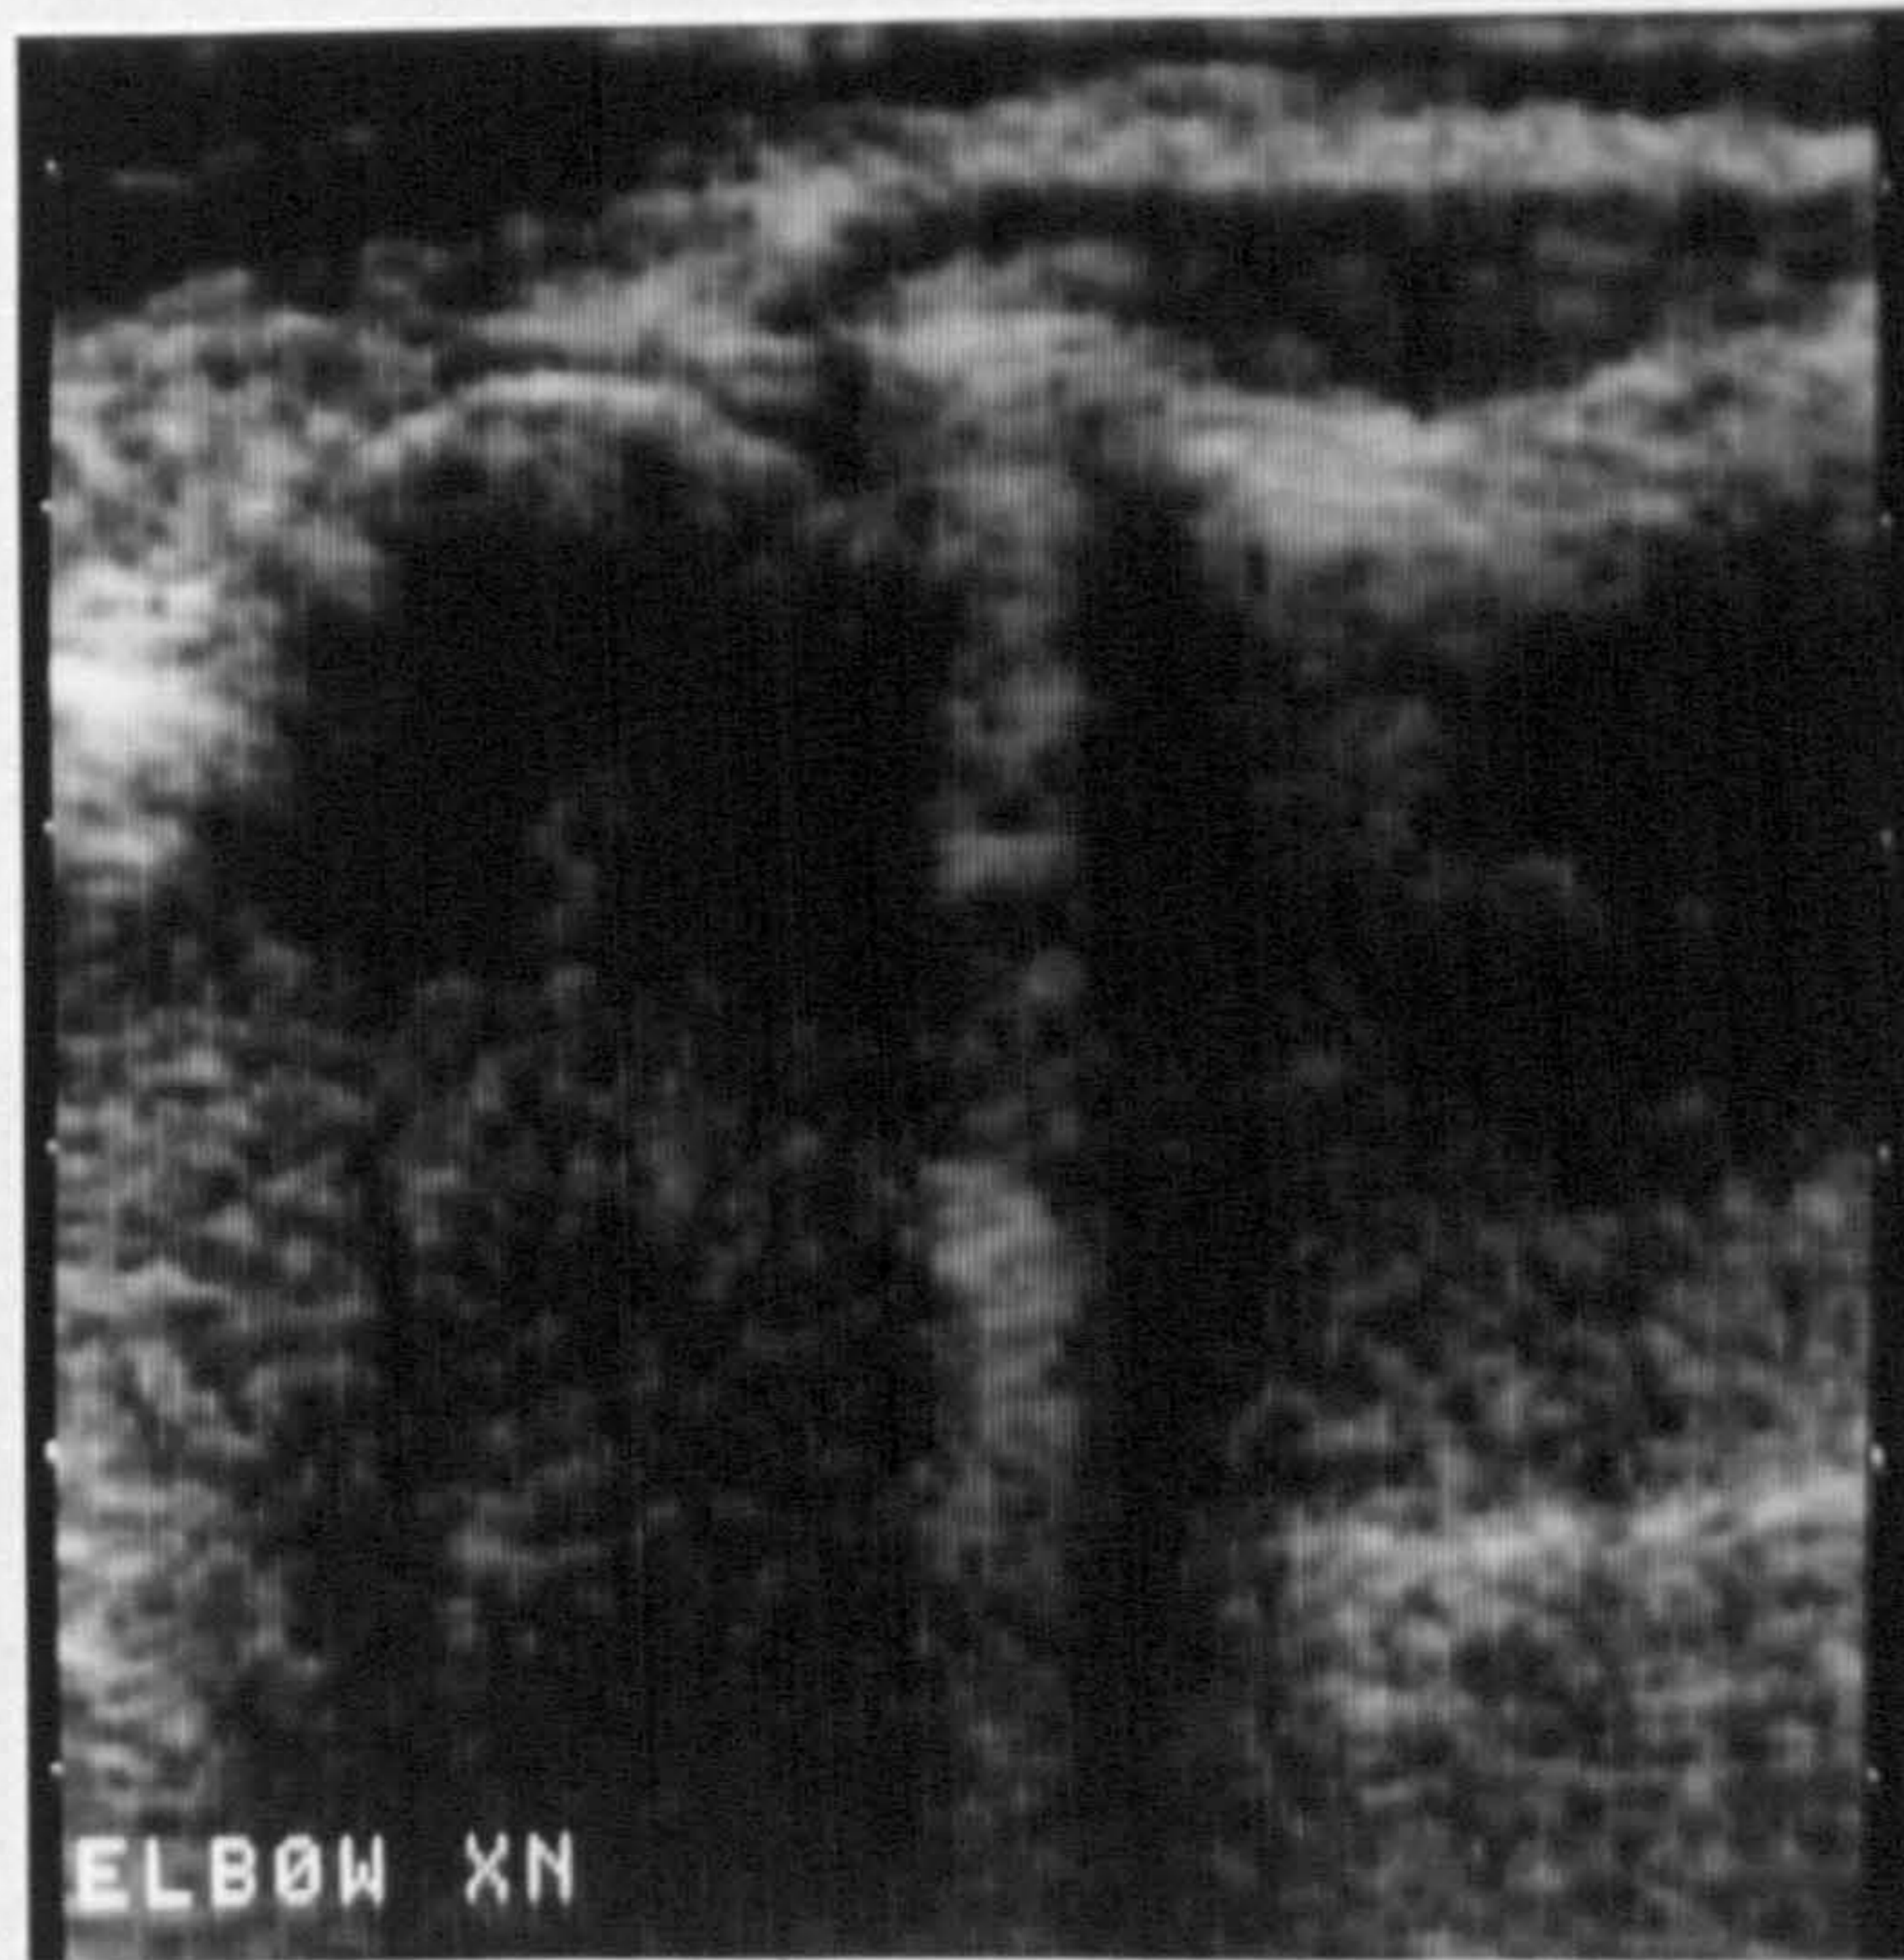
b Ultrasound scan : right elbow
